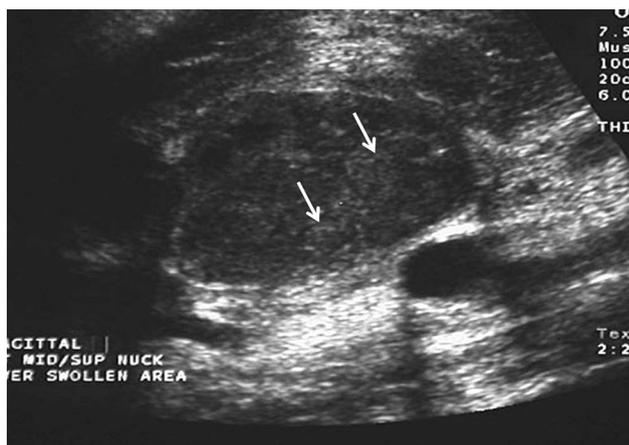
US study. Gray scale sonography showing a cluster of pathologically enlarged lymphomatous cervical nodes. Intranodal reticulations that obscure the normal fatty hila and other more normal internal nodal architecture are present (arrows). (Courtesy: Dr. Christos Angelopoulos; New York, NY, USA)
